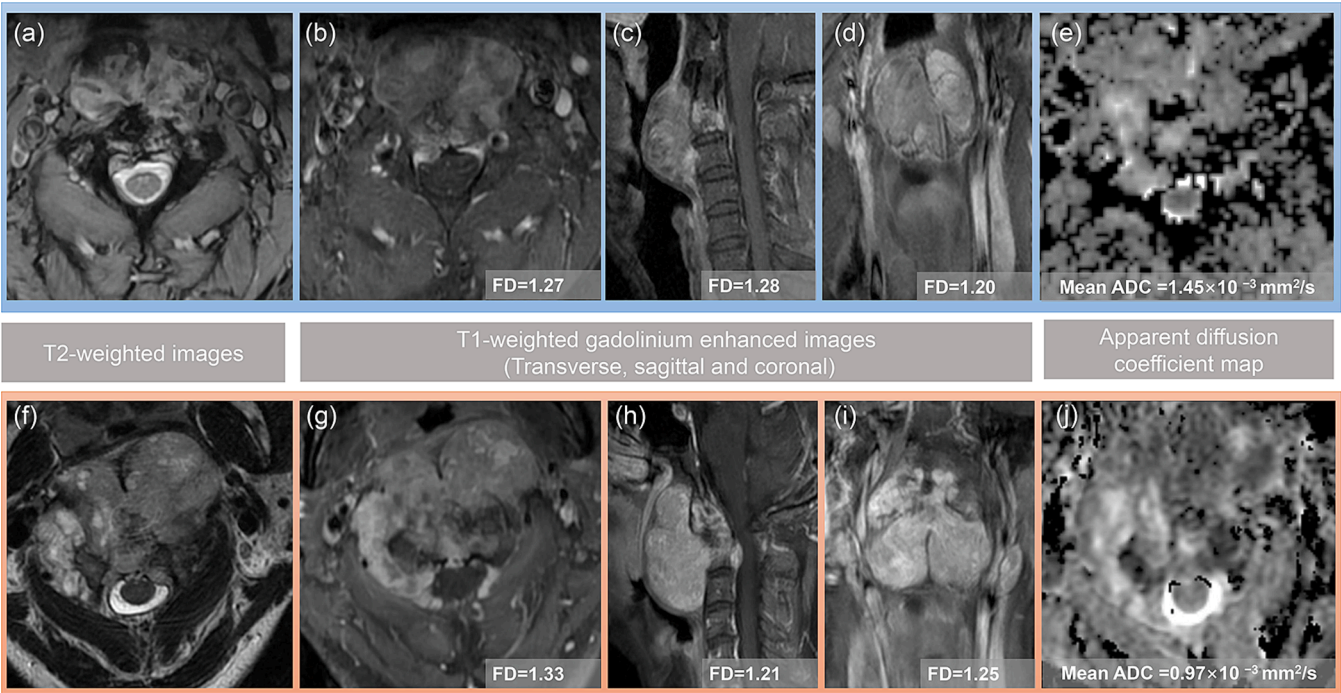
MRI images of two cases with pathologically confirmed chordoma. (a–e) A 49-year-old male, and no recurrence was observed after 5 years of follow-up; (f–j) A 43-year-old male, was diagnosed with tumor recurrence 11 months after surgery. The FD and mean ADC of the shown layer are listed. Compared to FD, ADC values showed a more noticeable decrease. FD, fractal dimension; ADC, apparent diffusion coefficient.
